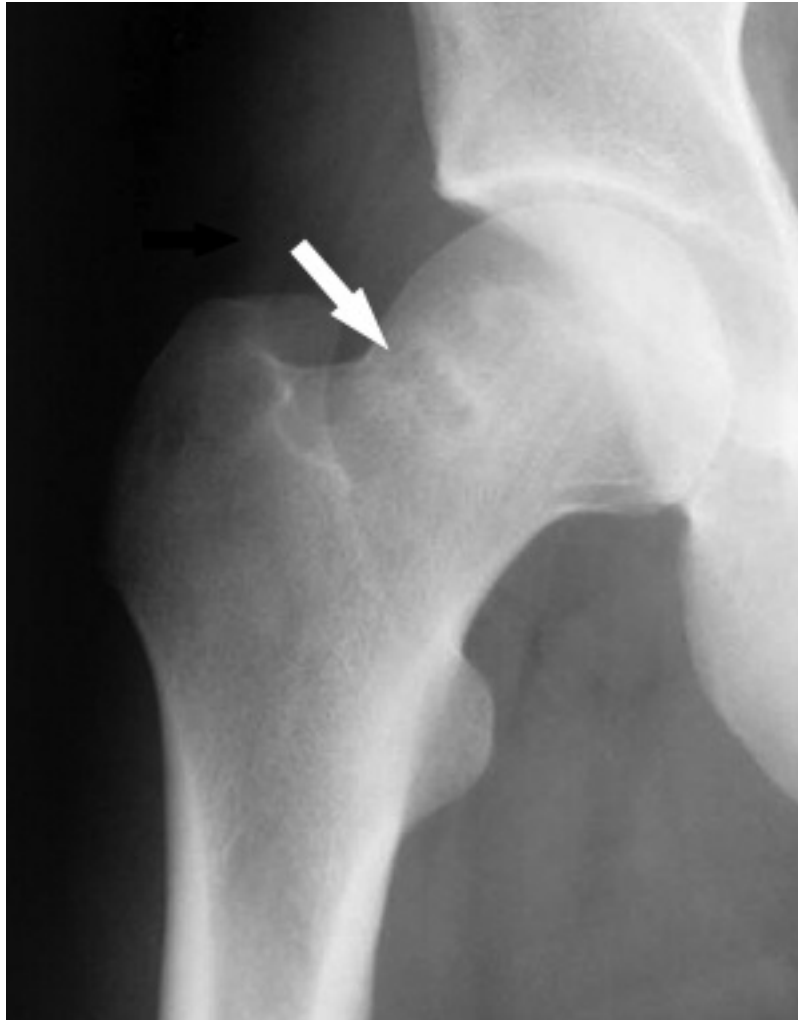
Herniation pits appear as lucent areas at the femoral head-neck junction area in plain radiographs.
